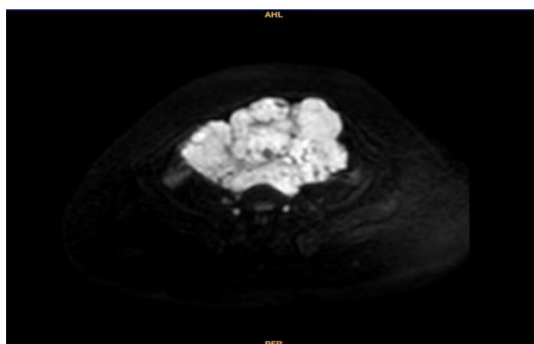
Axial section of DWI sequence, read at B-1000mm<sup>2</sup>/sec, showing high signal intensity mass in pelvis with low signal intensity septa.
